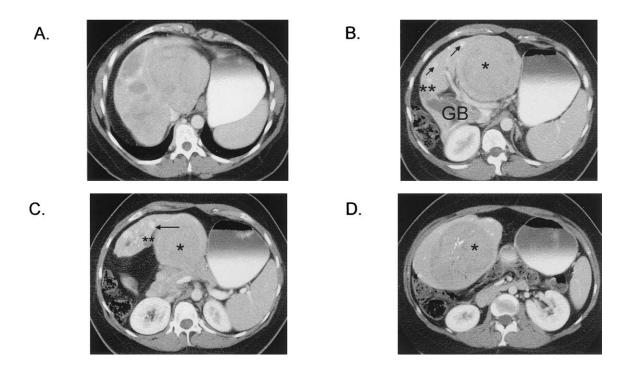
Portal venous phase CT images of multiple FNH at multiple levels from superior to Inferior. A, There is a large heterogeneous mass in the left lateral segment, which is predominantly hypodense to normal liver. The adjacent medial left and right lobes are diffusely heterogeneous, containing multiple hypodense lesions that are difficult to individually discriminate. B, Portal venous phase at the same level as in Fig. 1, *A*. The exophytic lateral left segment lesion (*) is again seen, appearing more hypodense to liver. A smaller hypodense lesion () is seen next to the gallbladder. Small hyperdense foci (*arrowheads*) represent dilated hepatic veins. C, The inferior portion of the exophytic left lateral segment lesion is seen (*). Another small left medial hypodense lesion () is evident, as are dilated hepatic veins (*arrowhead*). D, The second large exophytic segment IV lesion (*) is evident, appearing more hypodense to liver with unchanged foci of calcification.
